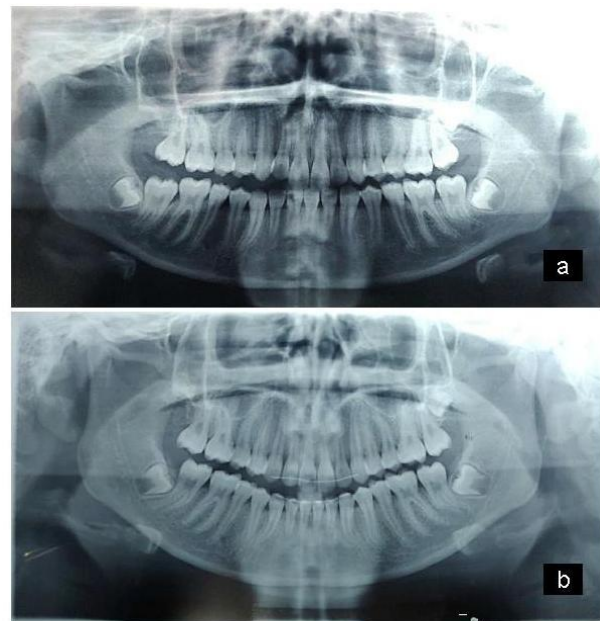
Orthopantomogram a; Pretreatment, b Post treatment
